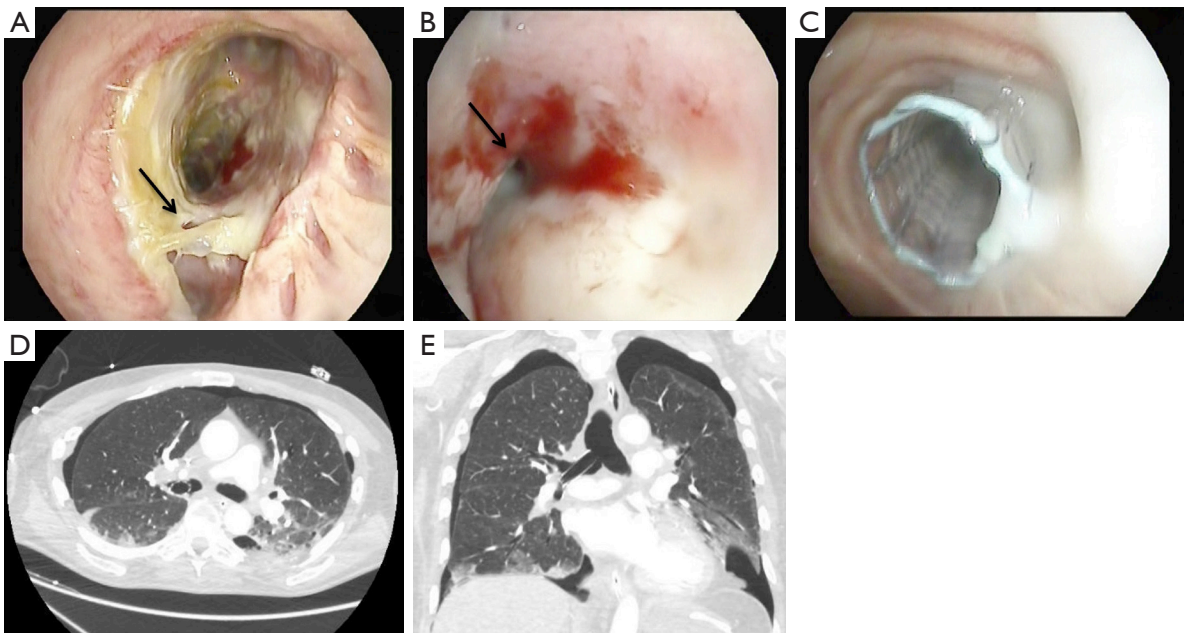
Endoscopic and radiological view of a bronchopleural fistula. (A,B) Mild bronchopleural fistula after double lung transplantation for COPD (arrows); (C) Ultraflex stent deployment; (D,E) chest CT scan after stent placement: bilateral pneumothorax. CT, computed tomography; COPD, chronic obstructive pulmonary disease.
